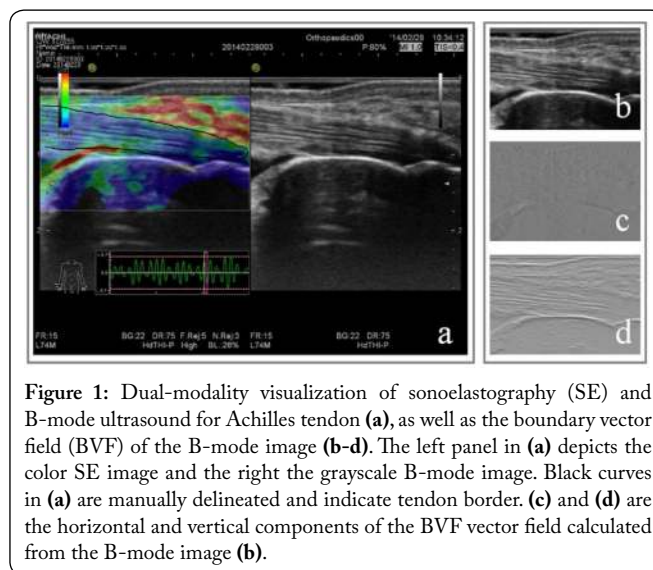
Dual-modality visualization of sonoelastography (SE) and B-mode ultrasound for Achilles tendon (a), as well as the boundary vector field (BVF) of the B-mode image (b-d). The left panel in (a) depicts the color SE image and the right the grayscale B-mode image. Black curves in (a) are manually delineated and indicate tendon border. (c) and (d) are the horizontal and vertical components of the BVF vector field calculated from the B-mode image (b).
